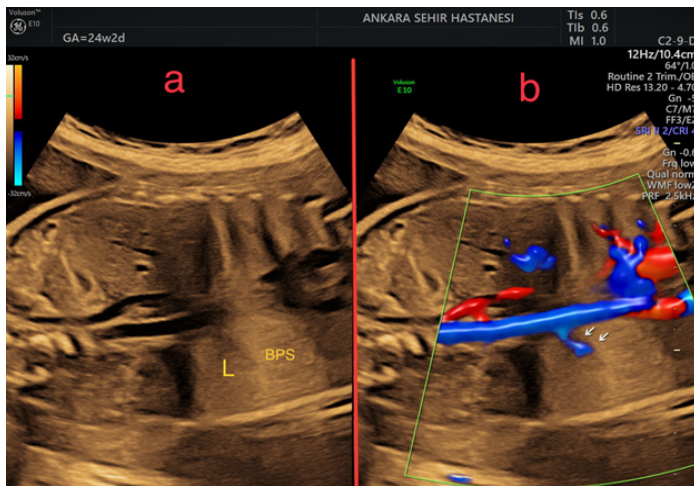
Bronchopulmonary sequestration. a Coronal sonographic image at 24 weeks of gestation shows a hyperechoic wedge-shape mass (BPS) at the posteroinferiorleft lung . The normal intermediate echogenicity lung parenchyma (L) is visible. b Power Doppler US image of the same iamge shows a feeding vessel (arrow) from the descending thoracic aorta supplying the bronchopulmonary sequestration
